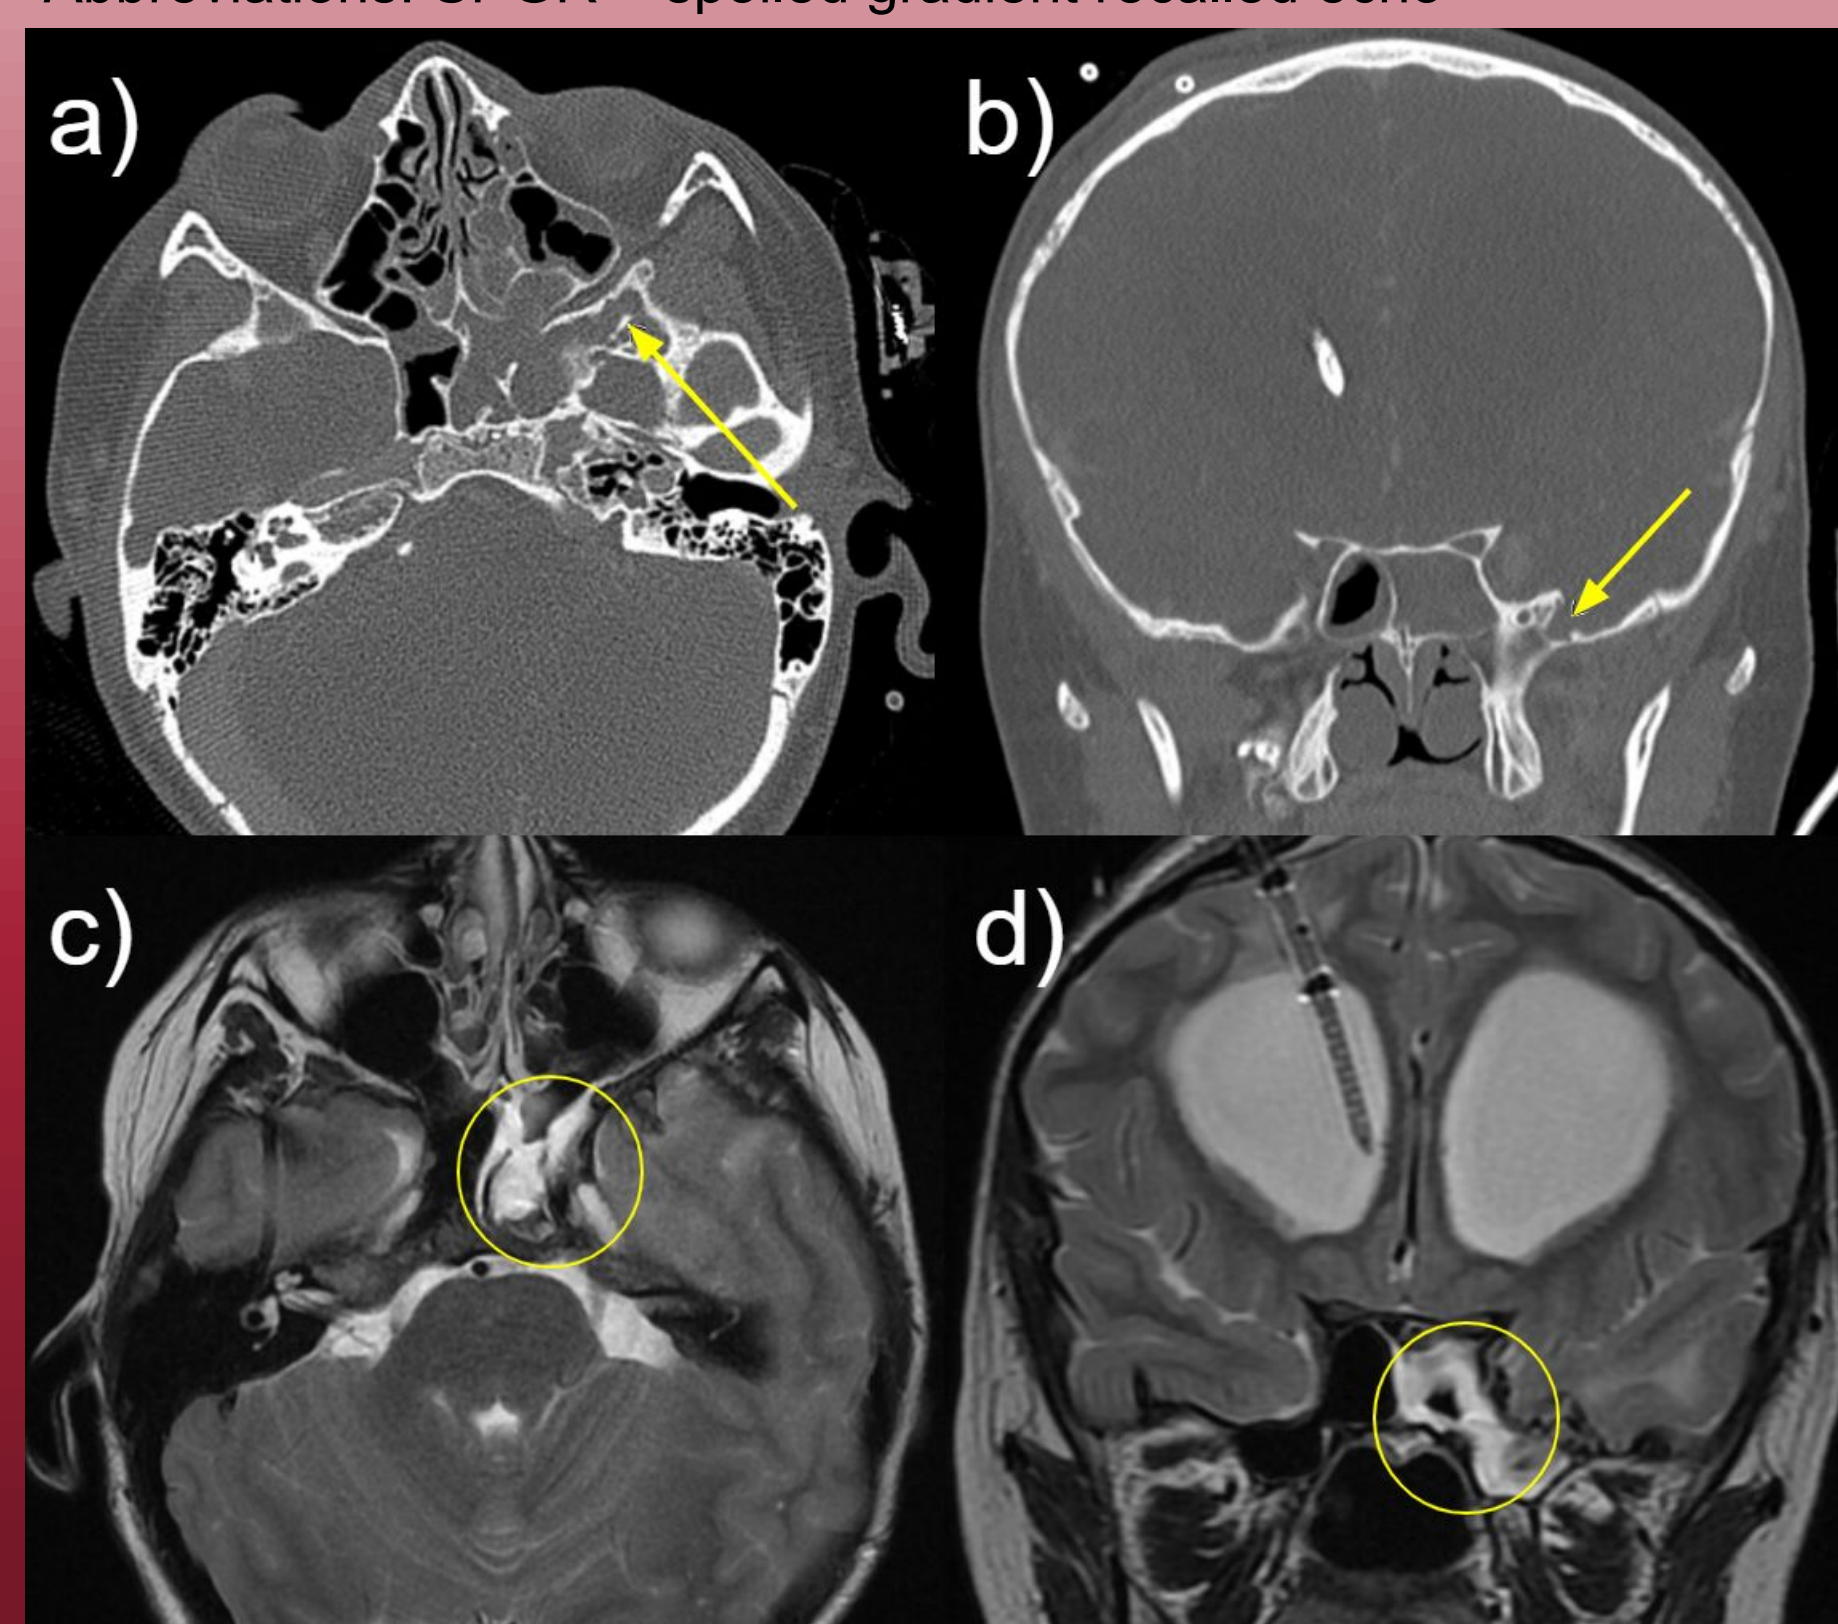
CT scan in the (a) axial and (b) coronal planes demonstrating a left sphenoid sinus lateral wall defect. Noncontrast T2 MRI in the (c) axial and (d) coronal planes demonstrating enhancement of the protruding encephalocele tissue in the left sphenoid sinus.
